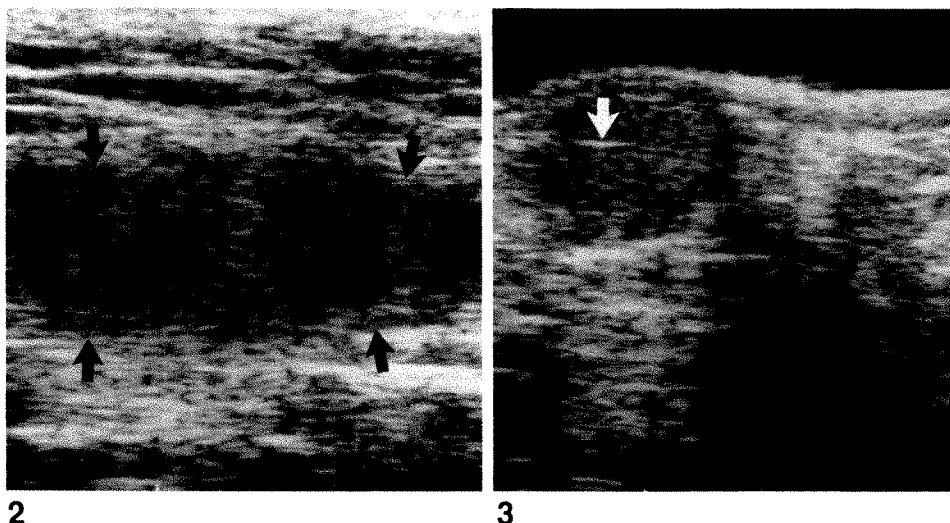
Pars infravaginalis gubernaculi mimicking the testis on a longitudinal sonogram in a 6-year-old boy. A left inguinal structure (arrows) is identified that has internal echoes but not a mediastinum testis. This proved at surgery to be the pars infravaginalis gubernaculi. No testis was present on that side.
